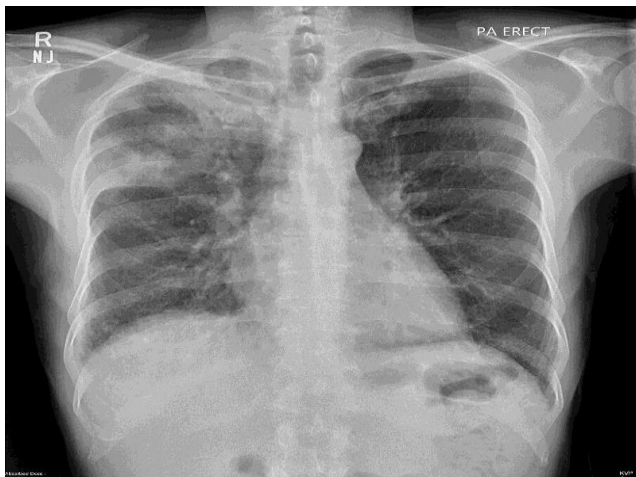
Chest X-ray PA view of HIV negative PTB patient demonstrating alveolar infiltrates in right upper zone.
